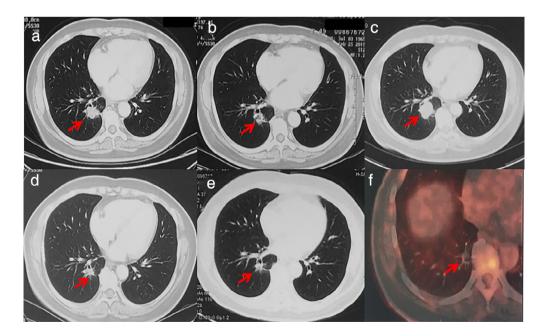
Radiographic response to ceritinib after progression on crizotinib. Enhanced chest computed tomography (CT) changes after targeted therapy. (a) Remarkable reduction of the lung nodule $(2.6 \times 1.9 \text{ cm})$ was seen after one month of treatment with crizotinib. (b) Serial imaging showed a partial radiological response according to response evaluation criteria in solid tumors (RECIST 1.1). (c) Nineteen months after the initial diagnosis, an enlarged lung nodule $(3.1 \times 2.6 \text{ cm})$ indicated disease progression, and treatment was switched to ceritinib. Response after (d) eight and (e) sixteen weeks of treatment with ceritinib. (f) An irregular patchy nodular shadow (SUVmax1.3) was seen on 18F-FDG-positron emission tomography-computed tomography (PET-CT)
